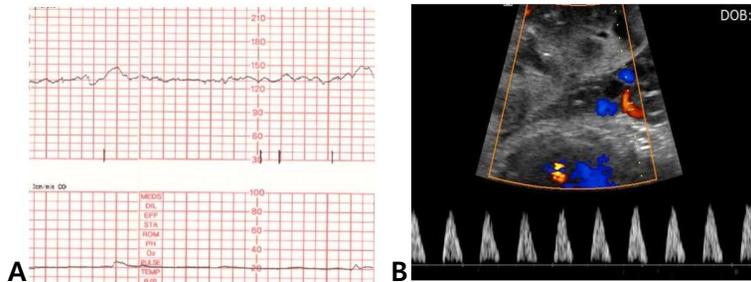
Results of antepartum fetal surveillance at 37⁺⁴ weeks' gestation: (A) Normal nonstress test; (B) Doppler waveforms with absent end-diastolic flow velocity in the umbilical artery.
